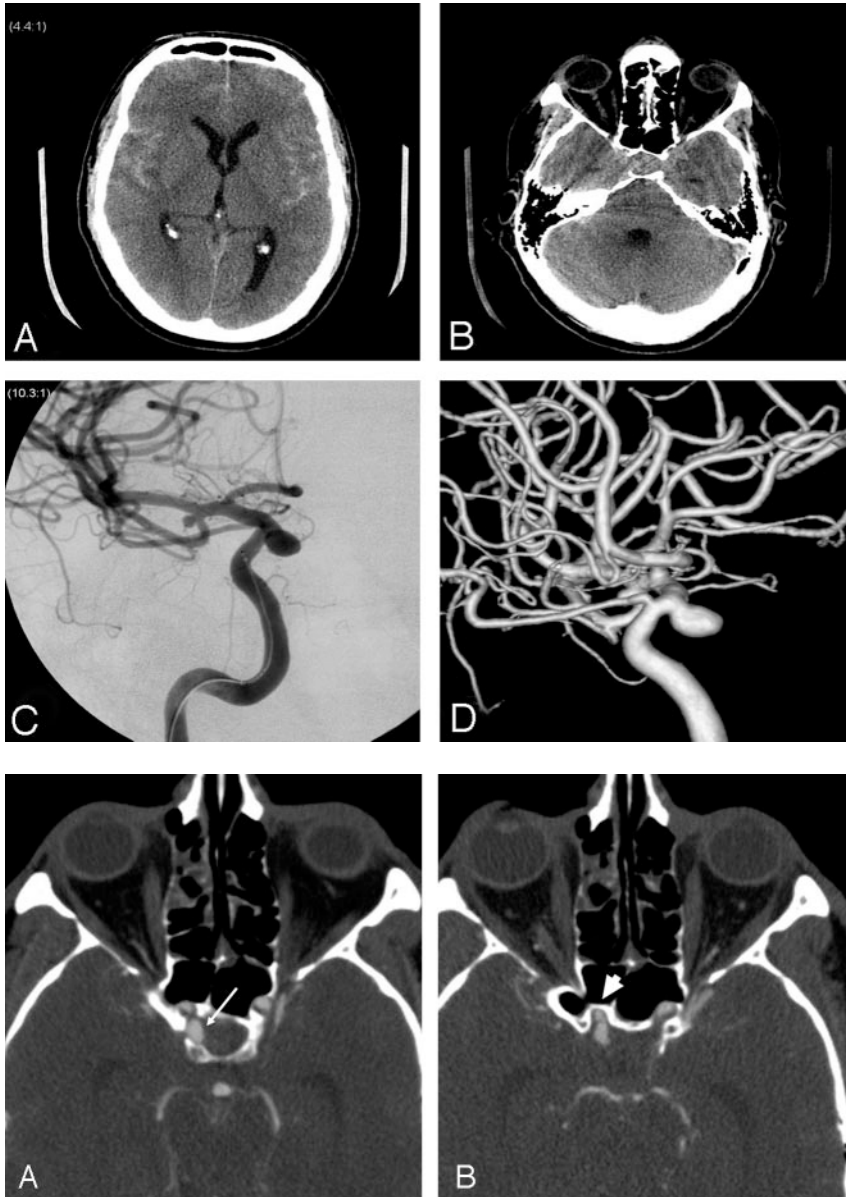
A, Axial unenhanced CT shows diffuse symmetric subarachnoid hemorrhage. B, Questionable hyperattenuation at the level of the sella turcica is difficult to interpret given adjacent streak artifact. C, Frontal view of right internal carotid angiogram shows MCA bifurcation and paraclinoid aneurysms. D, 3D right ICA angiogram in lateral view reveals the paraclinoid aneurysm arising distal to the ophthalmic artery but pointing inferiorly below the plane of the ophthalmic artery.
